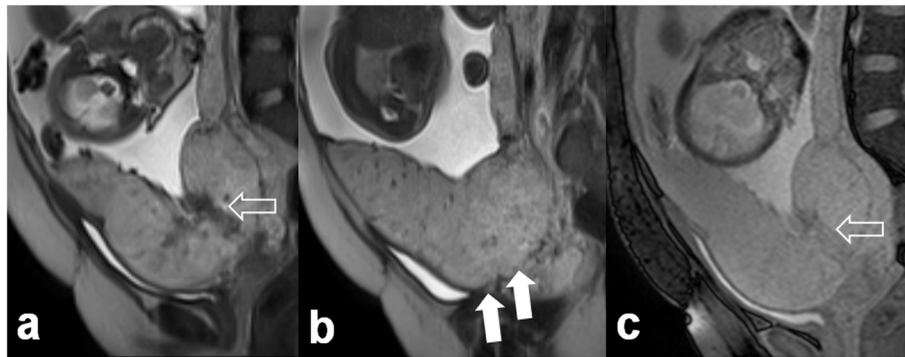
A 23-year-old woman (gravida –2) with history of previous Caesarean section. The sagittal T2 HASTE (a, b) and SSFP (c) MR images show placenta previa with dark bands (open arrows) and loss of uteroplacental interface (arrows). Since placenta accreta was present during elective Caesarean section, uterine artery embolization was performed and she was placed on follow-up
